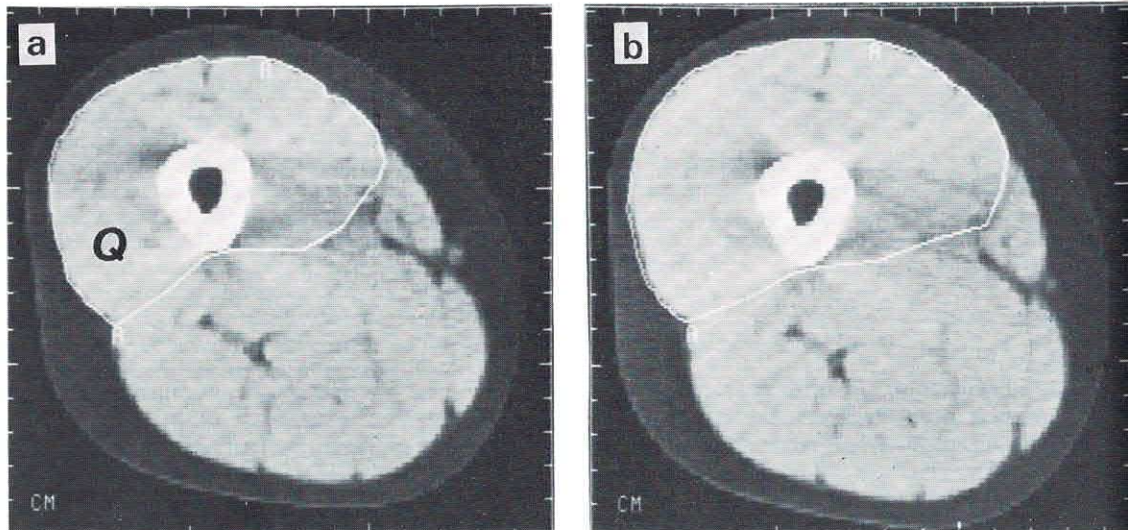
Computerised tomography (CT) scans taken at half femur height in the injured leg before (a) and after (b) six months strength training. Q = quadriceps.
